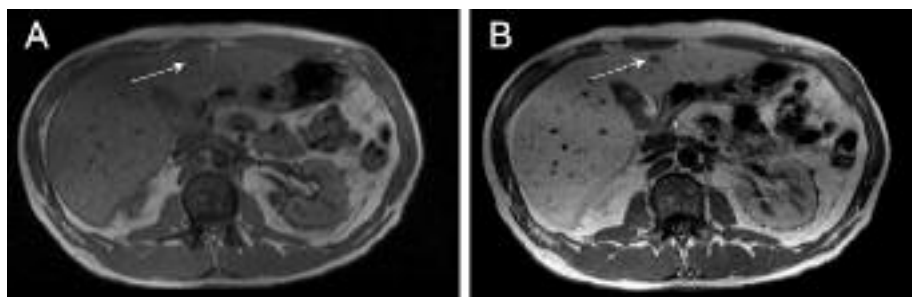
Mangafodipir trisodium as hepatospecific contrast media for MRI
